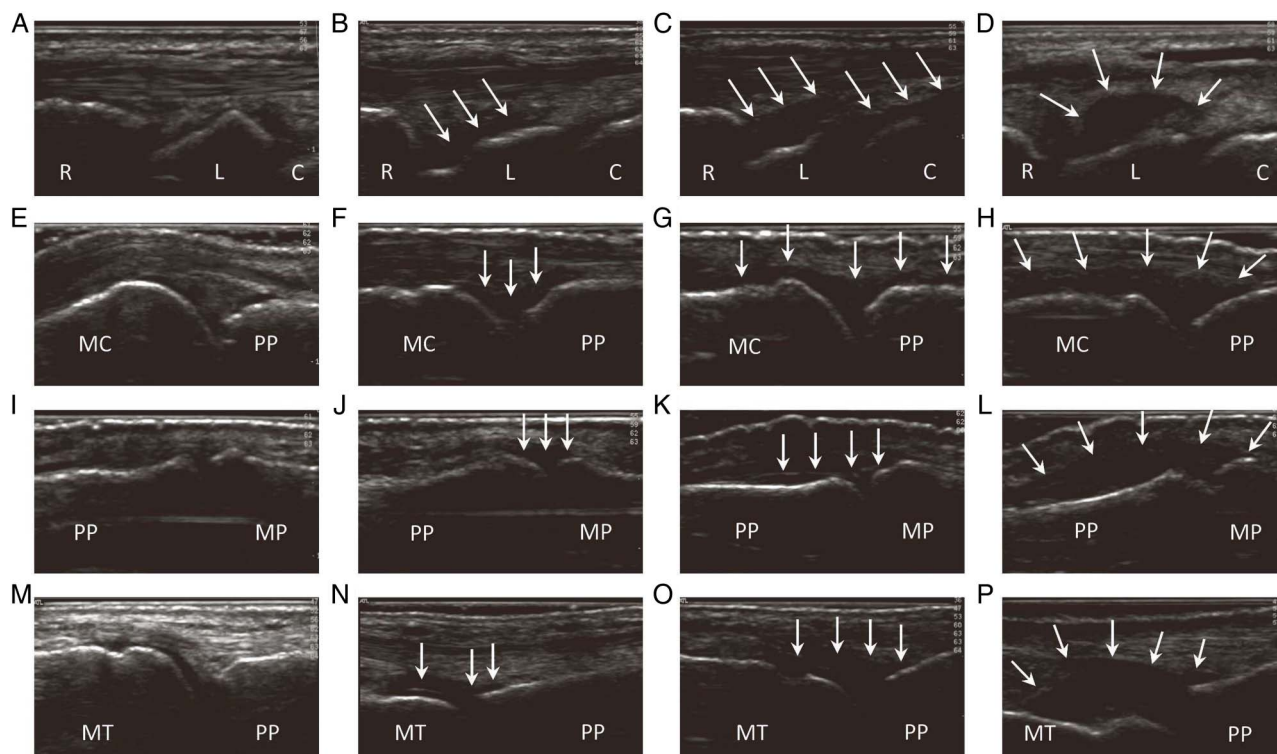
Spectrum of ultrasound grey scale on the dorsal aspects of the wrists ((a) to (d)), MCPs ((e) to (h)), PIPs ((i) to (l)) and MTPs ((m) to (p)): grade 0 ((a), (e), (i) and (m)), grade 1 ((b), (f), (j) and (n)), grade 2 ((c), (g), (k) and (o)) and grade 3 ((d), (h), (l) and (p)). Courtesy of J. L. Nam *et al*, Leeds, reproduced with permission from *Annals of the Rheumatic Diseases*.¹⁸ C, capitate; L, lunate; MC, metacarpal; MCPs, metacarpophalangeal joints; MP, middle phalanx; MT, metatarsal; MTP, metatarsophalangeal joints; PIPs, proximal interphalangeal joints; PP, proximal phalanx; R, radius.
